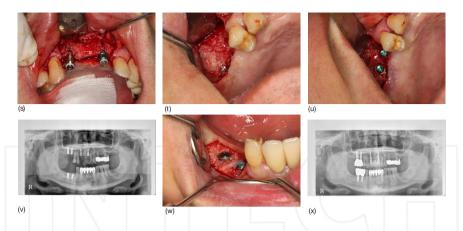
Placement of implants after the ridge augmentation of the maxillary anterior and maxillary/mandibular posterior area. a): Panoramic radiography at the first examination. Alveolar resorption was in considerable progress on the whole. b): Intraoral photograph taken just before the ridge augmentation of the maxillary anterior area. One month passed after extraction. c): View of the elevated mucoperiosteal flap. The labial side concavity is observed. d): View of fixation with titanium screws after applying the AutoBT block on the labial side. e): View of grafting the AutoBT powder additionally. f): Sutured after covering the resorbable collagen membrane (Ossix plus). g): View of the sinus bone graft on the right side using the AutoBT powder. h): View of fixation with titanium screws after vertical ridge augmentation with the AutoBT block. i): Panoramic radiography after grafting the bone on the maxillary anterior area and the right posterior area. j): Intraoral photograph prior to the right mandibular posterior bone grafting. One month passed after extraction. k): View of the elevated mucoperiosteal flap. The vertical bone defects on the ridge is observed. I): After applying the AutoBT block on the #45 area, the AutoBT powder was grafted on the surrounding sites. The AutoBT block was hydrated in saline solution for 15 ~ 30 minutes and operated. m): After covering the Ossix plus, the wound was closed. n): Panoramic radiography after bone graft. o): View of the elevated mucoperiosteal flap on the #45 and 46 sites after 2 months of ridge augmentation. Some Ossix plus that were not resorbed is observed, p): After removing Ossix plus, very excellent bone healing was observed, a): View of #45 and 46 implant placement, r): View of the elevated mucoperiosteal flap on the maxillary anterior area 4 months after bone grafting. Good bone healing is observed. There was not much bone resorption when the state of titanium screws was examined. s): After removing the titanium screws, the implants were placed. t): Exposed #15 and 16 areas. The titanium screws fixing the block is observed, and bone healing was very good. u): View of implants placed on the site. v): Panoramic radiography after the #12, 21, 15, and 16 implants were placed. w): View of the #45 and 46 implants exposed while doing the secondary surgery after 2 months. x): Panoramic radiography 6 months after the final prosthetic delivery.
